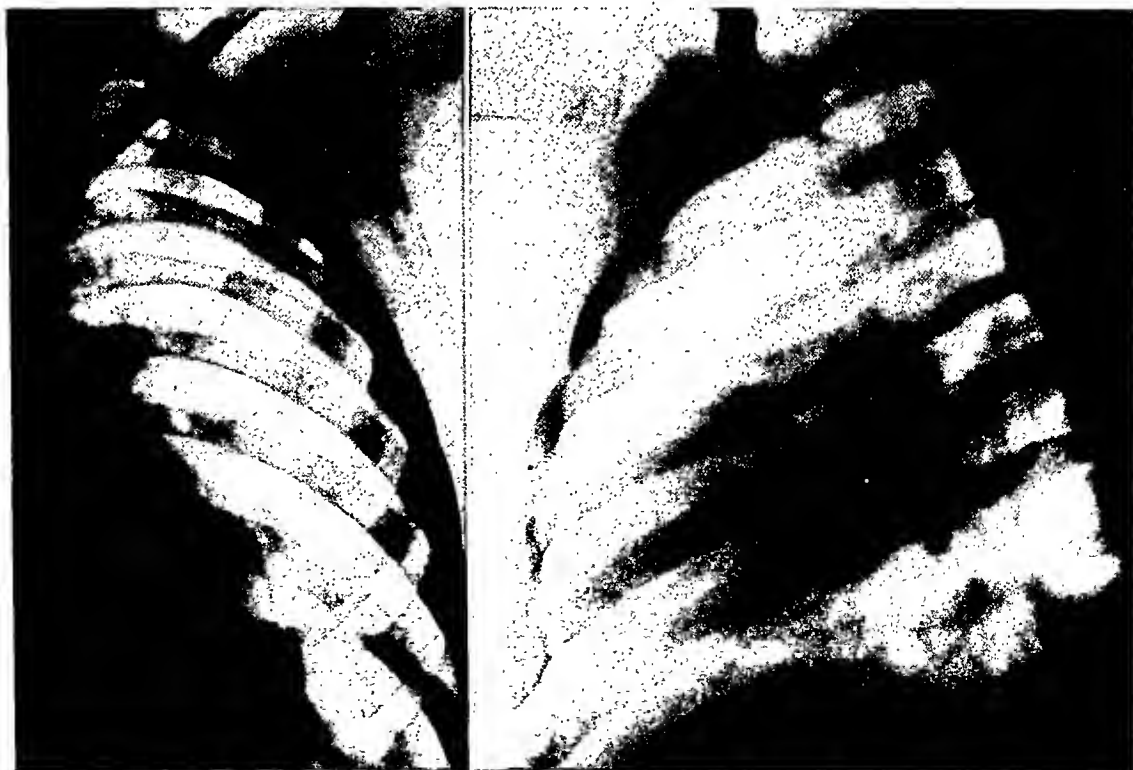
Same case as Figure 3; roentgenographs taken 32 hours later (see text). Lung-fields now perfectly clear. Diaphragm lower than before.
